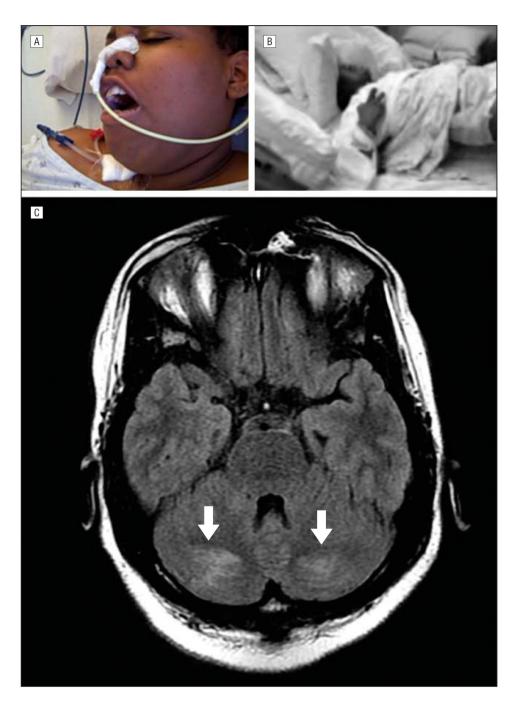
Jaw-opening dystonia (A) and opisthotonic posture (B) are observed. C, A fluid-attenuated inversion recovery sequence of an axial brain magnetic resonance image shows symmetric hyperintensities in the cerebellar hemispheres (arrows).
